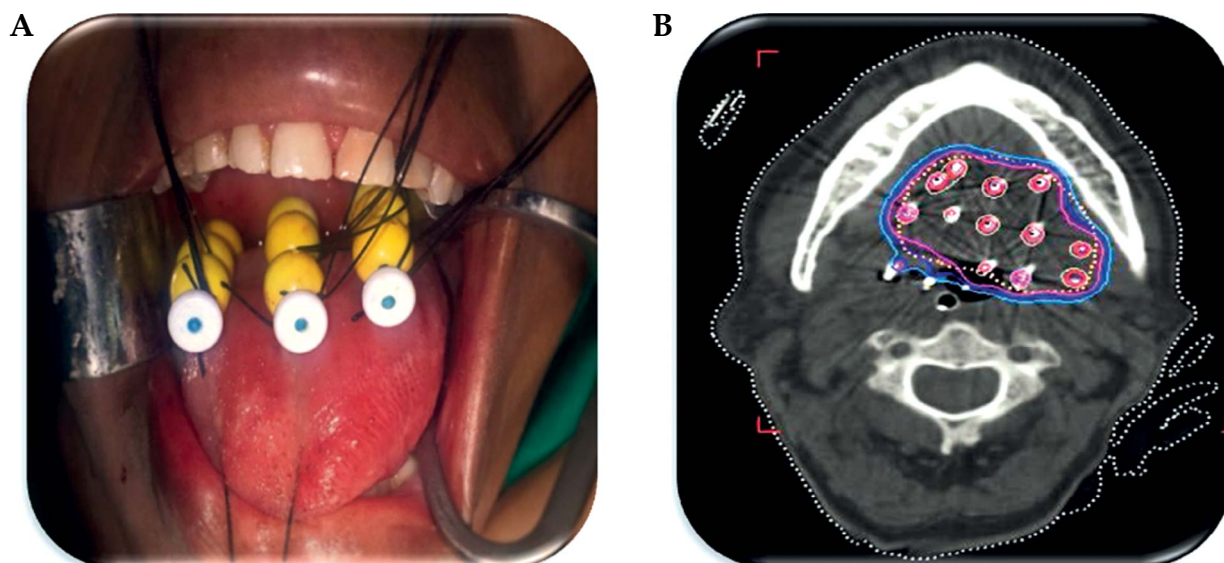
A) Plastic bead placement using Bhalavat's technique. B) Computed tomography image of the implant with catheter reconstruction and planning
